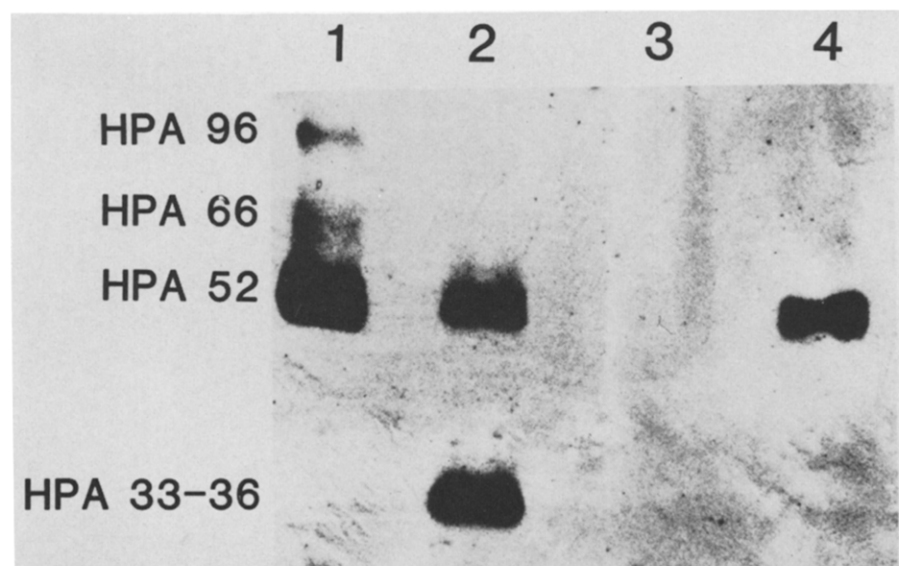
Effect of minactivin on plasminogen activator in the culture supernatant of COLO 394 cells. Lane 1, culture with no additions; lane 2, with plasminogen; lane 3, with plasminogen and minactivin (titration equivalent of 1.4 CTA U urokinase); lane 4, with plasminogen, trasylol and minactivin. Zones of lysis are: plasminogen activator of M, 96,000 (HPA 96); HPA66; HPA52 and HPA 33-36.
